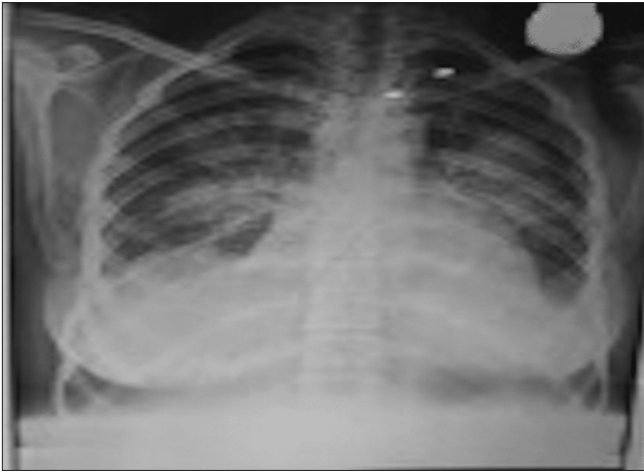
Chest X-ray demonstrating pulmonary oedema
